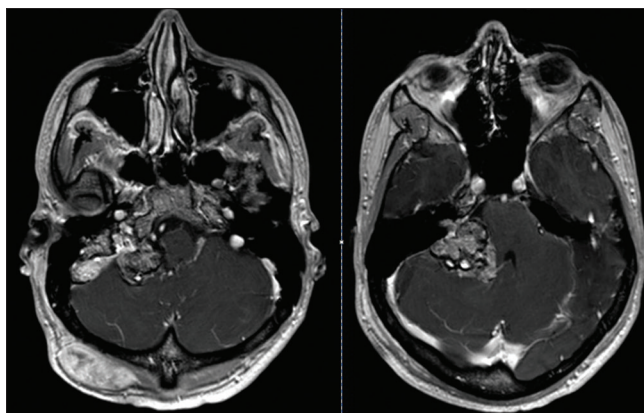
Preoperative contrast enhanced magnetic resonance imaging
